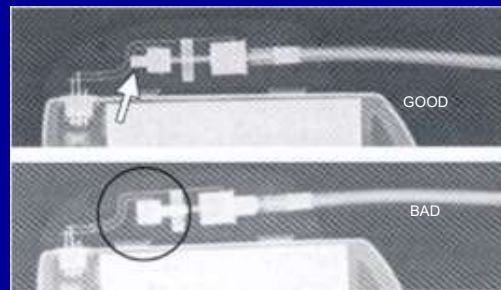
Radiograph demonstrating proper extension of the connector pin beyond the set screw. Top: arrow indicates fluoroscopic image of a pacemaker header with properly implanted lead pins and adequate extension beyond the set screw. Bottom: circle indicates improper lead pin position.
